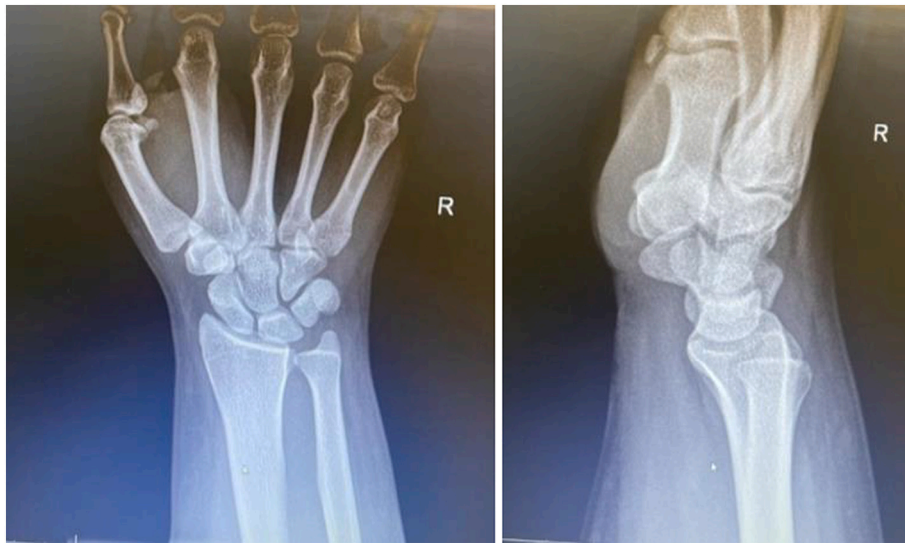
Hand and wrist X-rays were inconclusive.
